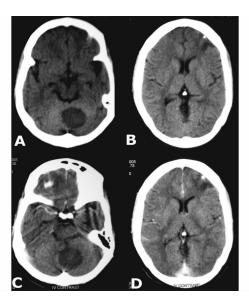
CT scan brain plain (A & B) and contrast (C & D) showing well defined hypodense lesion in the left cerebellar hemisphere and a calcified granuloma with peri-lesional oedema in left frontal lobe.
